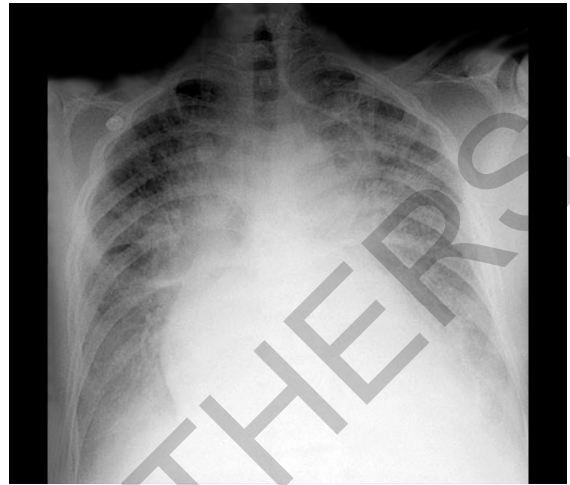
Chest X-ray—increased opacity, enlarged heart, prominent pulmonary vessels, and Kerley B lines.
